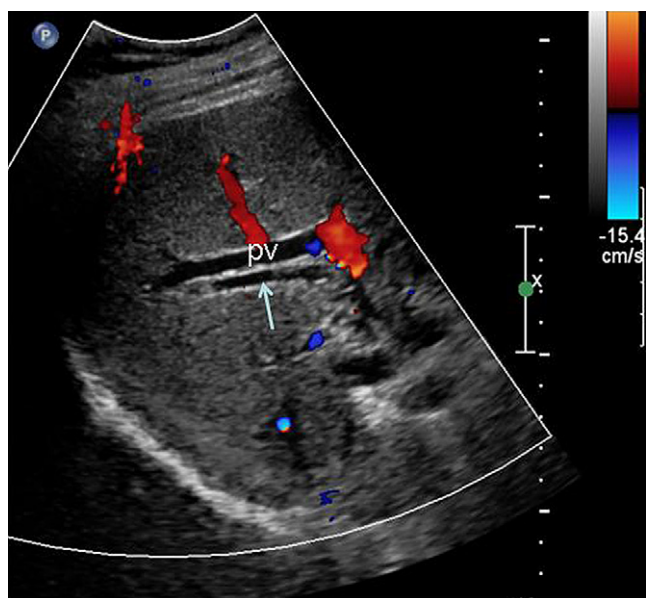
Normally the intrahepatic ducts (IHD) are not seen on ultrasound. When visualized it is usually indicative of biliary obstruction (arrow). Note the adjacent portal vein (pv). The proximity of the dilated IHD to the pv produces the so-called parallel sign.
